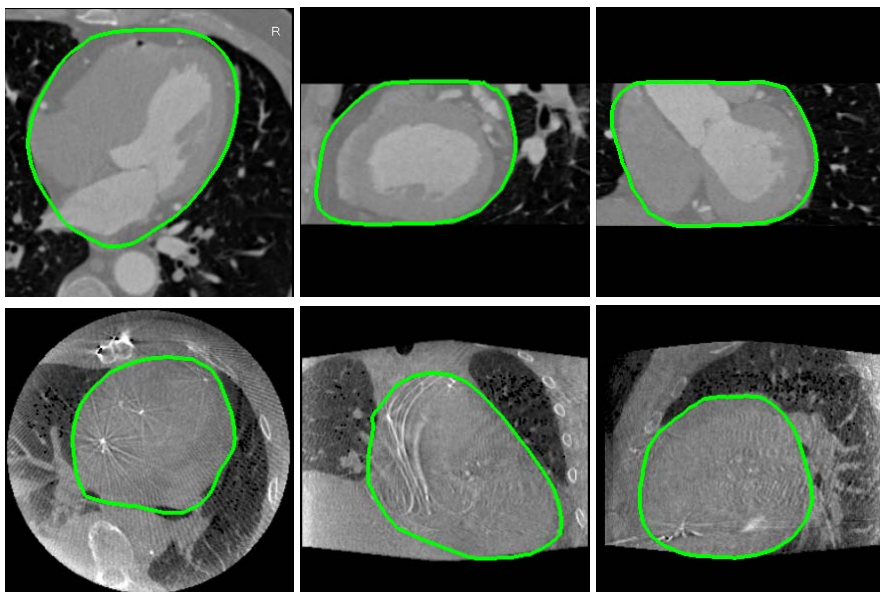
Pericardium segmentation on a contrasted CT scan (top row) and a non-contrasted C-arm CT scan (bottom row). From left to right three orthogonal cuts of the volume are shown.
